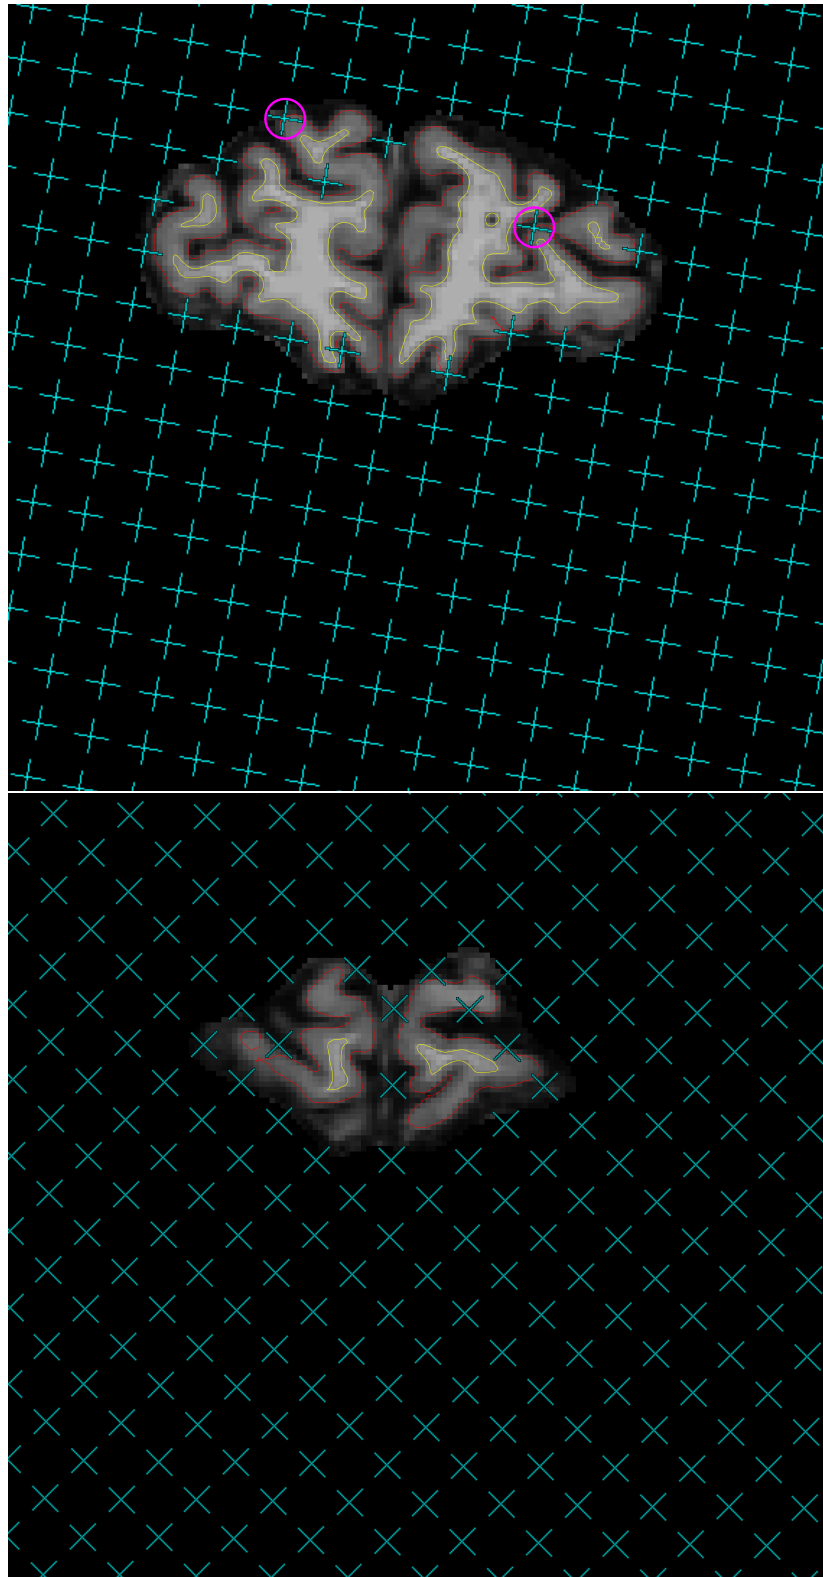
On the 15th and 16th slices of one brain MR image in the coronal view, uncounted test points (cyan) which miss the cerebral parenchyma or hit the ventricles are overlaid onto pial profiles (red lines) segmented by FREESURFER. Circles (pink) mark the uncounted test points which fall inside the grey matter boundaries (red lines).
